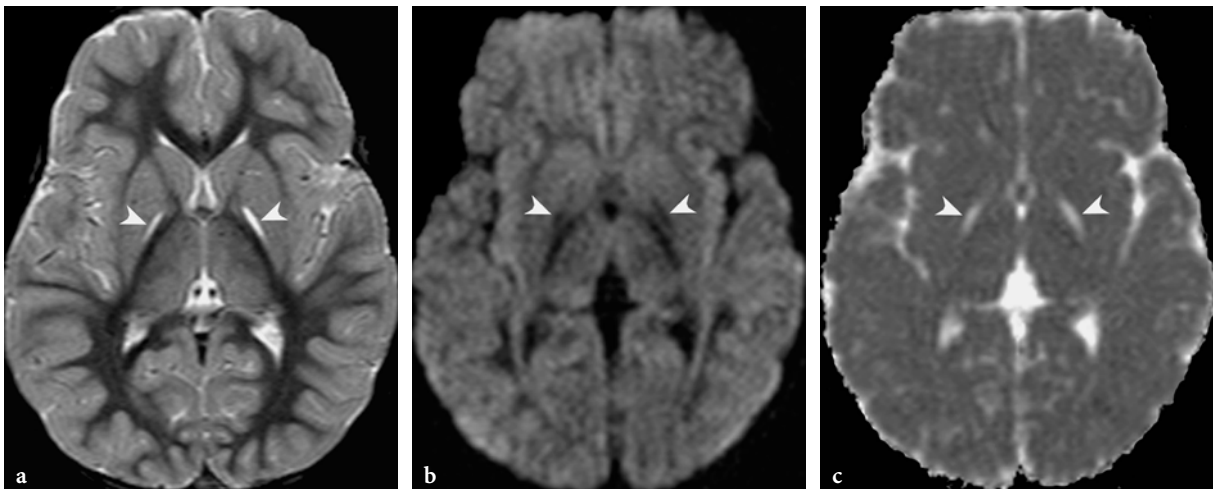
MR imaging findings in the chronic stage of methylmalonic acidemia in a 4-year-old female patient, who had an episode of acute metabolic decompensation in early infancy. a Axial T2-weighted modular inversion recovery image. The globi pallidi exhibit a slit-like appearance and are markedly hyperintense (*arrowheads*) (identical to CSF). b Axial diffusion-weighted echo-planar image. The lesions (lateral to the posterior limbs of the internal capsules) are hypointense (*arrowheads*), consistent with isotropically increased water diffusion, suggesting tissue necrosis. c Apparent diffusion coefficient (ADC) map image. The lesions are hyperintense (*arrowheads*), consistent with isotropically increased water diffusion
